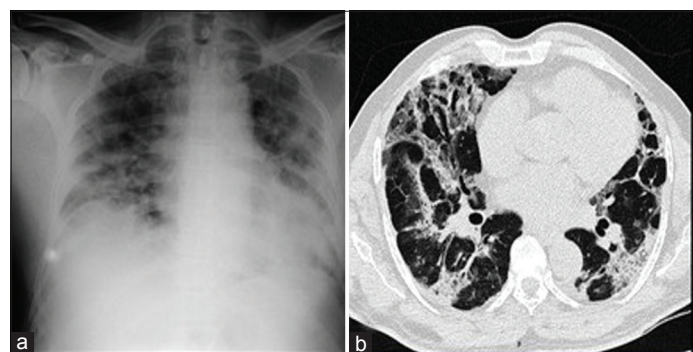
(a) Chest X-ray posteroanterior view at discharge shows bilateral patchy opacity; (b) CT chest shows diffuse patchy ground-glass opacity, peribroncho vascular, and interlobular septal thickening, traction bronchiectasis with evidence of fibrosis (Case 2)
